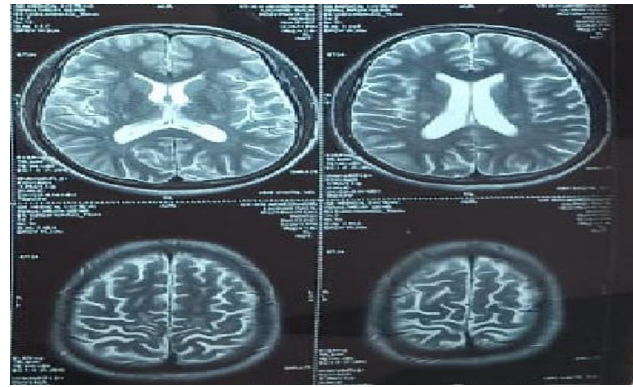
Bilateral restriction diffusion with T2 and FLAIR hyperintensities without blooming on SWI seen at bilateral centrum semiovale, along the corticospinal tract, posterior limb of internal capsule, ventrolateral aspect of midbrain and pons.
